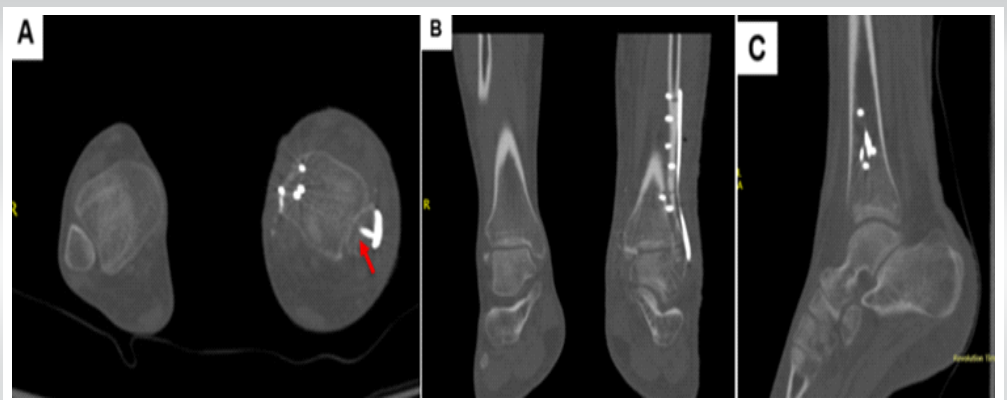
Computed tomography scan showing proper alignments of the fibular and medial malleolar fixations. Axial (a), coronal (b), and sagittal (c) views.
